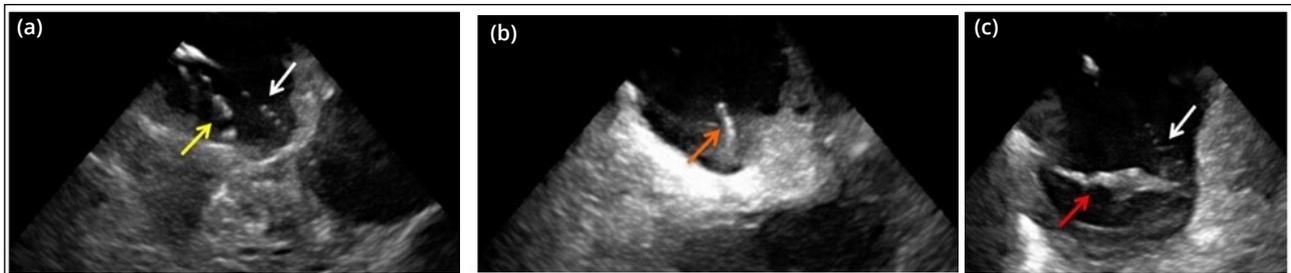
Intracardiac echocardiogram (ICE) guided catheter positioning: (a) ICE imaging showing a diagnostic decapolar catheter positioned in the coronary sinus (CS- yellow arrow) and a 4mm catheter ablation in the mapping zone. (b) ICE view of catheter ablation in the point of the Triangle of Koch where the slow pathway was ablated. (c) A more posterior ICE view shows the relation between the decapolar catheter in the CS (white arrow) and the tricuspid valve (red arrow).
